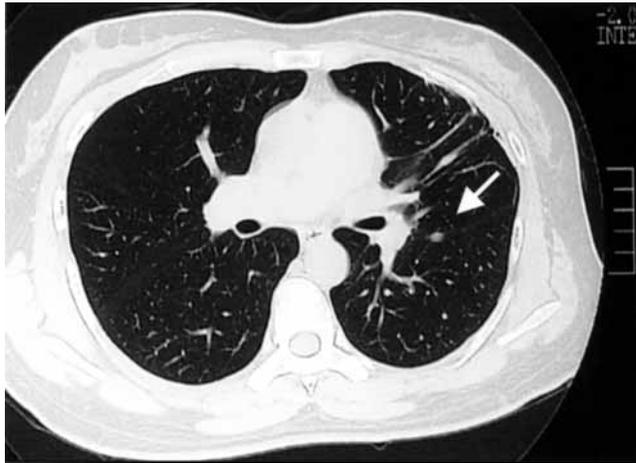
Thoracic CT image at the time of recurrence. A mass shadow measuring 7×5 mm was observed in S5 of the left lung (arrow).
